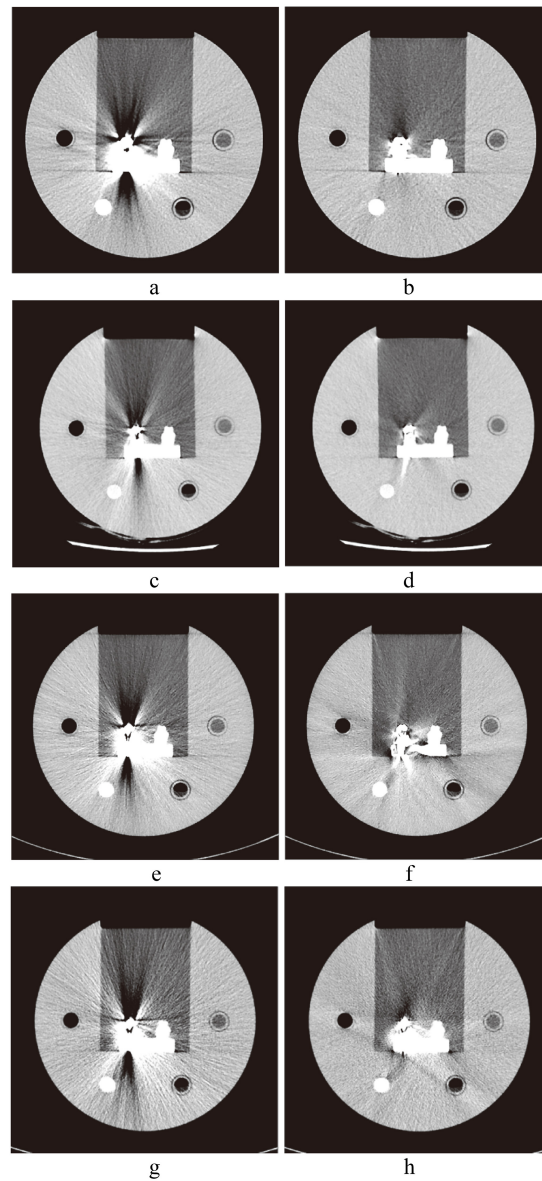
CT images of dental filling. a. Image without SEMAR; b. with SEMAR. c. Image without Smart-MAR; d. with Smart-MAR. e. Image without IMAR; f. with IMAR. g. Image without OMAR; h. with OMAR.
